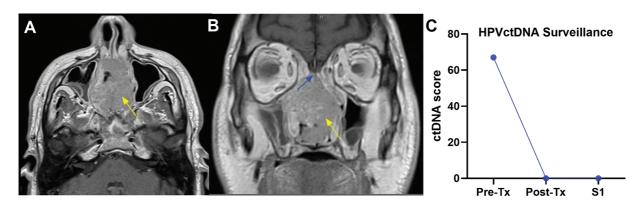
Axial (A) and coronal (B) views of maxillofacial MRI T1 with contrast demonstrating very large SNSCC filling the entire nasal cavity (yellow arrows), extending toward bilateral orbits, and causing bony erosion of right anterior skull base (blue arrow). Serial NavDx tests (C) show elevated ctDNA level pretreatment with no evidence of recurrence during the surveillance period following resection. SNSCC, sinonasal squamous cell carcinoma; ctDNA, circulating tumor DNA; MRI, magnetic resonance imaging; Tx, treatment; S1, surveillance #1.
